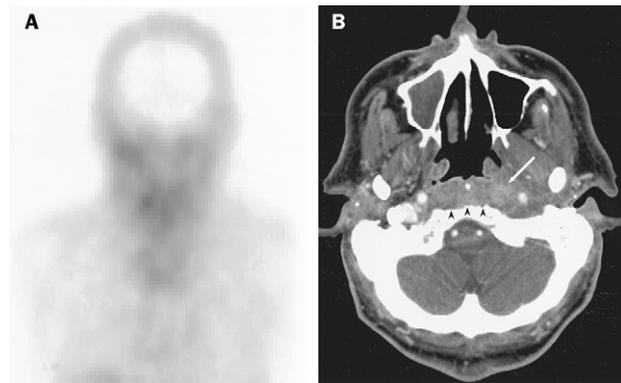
False-negative gallium scan. (A) Gallium citrate Ga67 was administered to assess the progression of known malignant external otitis. Coronal SPECT image shows no increased uptake. (B) CT 2 days later shows extensive inflammation of the soft tissues around the skull base (arrow), as well as erosion of the inferior surface of the clivus (arrowheads). Follow-up CT after further treatment (not shown) documented resolution of the soft tissue abnormalities.
